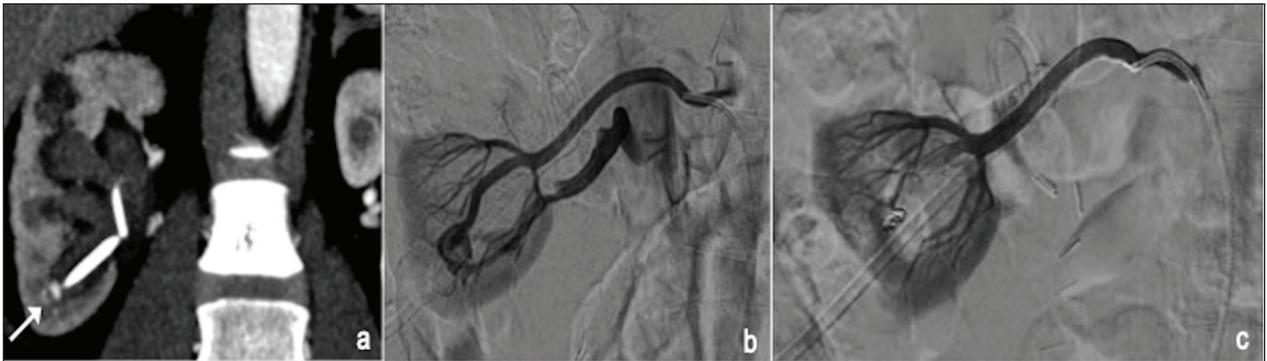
CT coronal view shows pseudoaneurysm (PSA) after nephrostomy (a); arteriogram confirms PSA and reveals an arteriovenous fistula also (b); final angiogram after embolization with coil (c).
